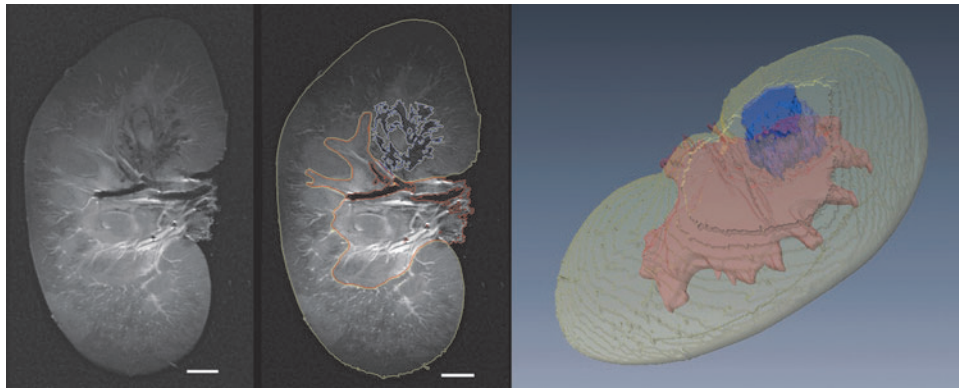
Example of image segmentation to enable volumetric injury quantification of functional renal tissue. The two images at *left* show a raw T2-weighted image slice and the same image segmented to define areas representing functional tissue (yellow lines), renal sinus (red lines), and hemorrhagic injury in functional tissue (blue lines). A three-dimensional reconstruction of these volumes is presented at *right*. Scale bar represents 1 cm.
